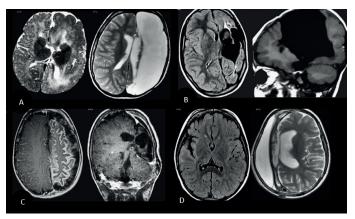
a) Hemimegaloencephaly. Axial T2w MRI shows extensive growth of the left hemisphere with enlargement of the white matter throughout the hemisphere, b) left porencephalic frontotemporal cyst affecting the basal ganglia and thalamus of the left ventricle with the dilated and exvacuo sylvian fissure, c) MRI of Sturge-Weber disease, axial T1w with gadolinium with cortical gyri in atrophic cerebral hemisphere. d) Rasmussen encephalitis. Preoperative axial FLAIR images, the subcortical white matter signal areas of the right insula are intensified, temporal and frontal lobes with parenchymal gliosis, with slight hemiatrophy of the right hemisphere.
